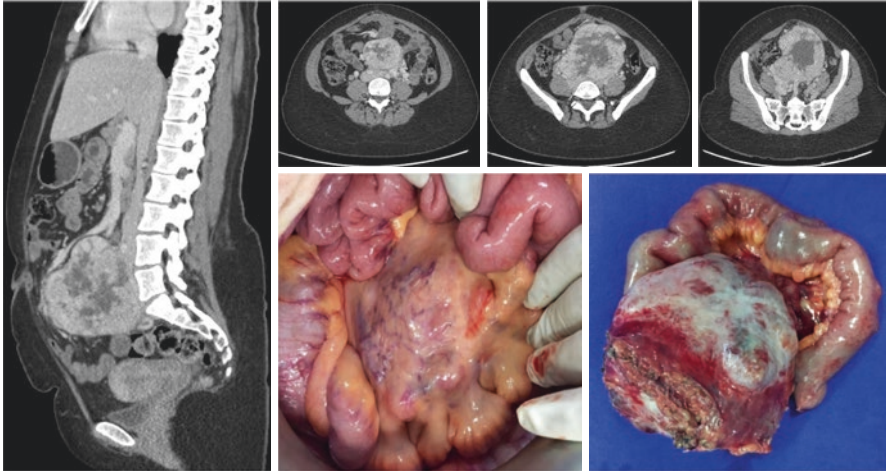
A 21-year-old female patient with abdominal mass found during obstetric ultrasound. Increased plasma catecholamines were found. After pregnancy, she was prepared for surgery with adrenergic block. The definitive diagnosis was paraganglioma. PASS calculation: Wide nests or diffuse architecture (in more than 10% of the tumor): 0 out of (2); central or confluent tumor necrosis: 2 out of (2); high cellularity: 0 out of (2); cell monotony: 0 of (2); spindle cell component: 0 of (2); mitosis figures $>3/10$ CGA: 0 of (2) (identified 01 mitosis in 10 HPF); atypical mitosis figures: 0 of (2); extension in adipose tissue: 0 of (2); vascular invasion: 1 of (1); capsular invasion: 1 of (1); accentuated nuclear pleomorphism: 0 of (1); nuclear hyperchromasia: 0 of (1) – *total score*: 04 = intermediate risk for malignancy. (Courtesy of Tibério Moura de Andrade Lima, surgical oncology)
